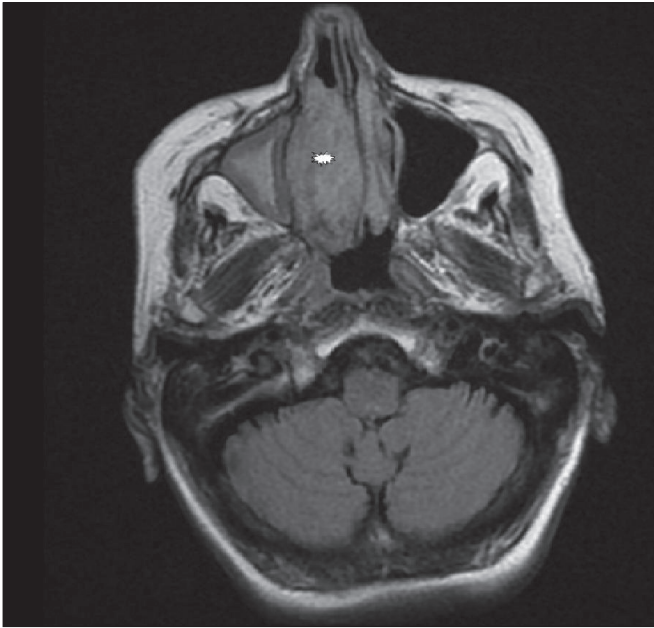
Mass lesion filling the right nasal cavity but not invading beyond (asterix) (MRI).
